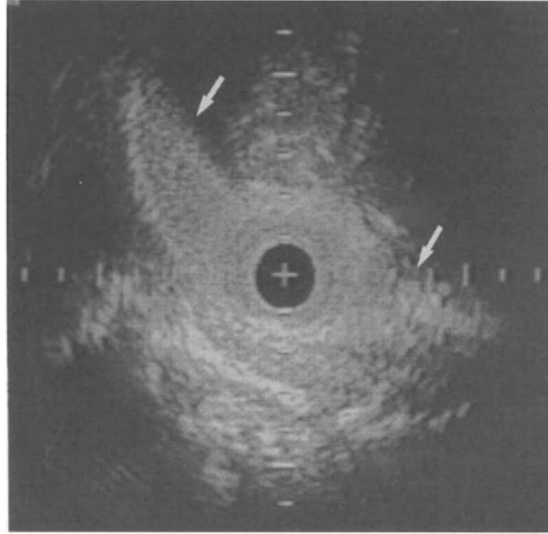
In vivo intravascular ultrasound image of a human femoral artery after balloon dilatation. The echogenic blood clearly delineates the vascular lumen. An almost complete drop-out, however, occurs in the segments in which the vessel wall and the underlying perivascular structures (arrows) are oriented at a narrow angle with the direction of the ultrasound beam. This sudden disappearance of the vessel wall can be clearly distinguished from drop-outs due to attenuation from blood, which would lead to a more progressive reduction in echo-intensity and would mainly affect the wall opposite to the position of the catheter. Courtesy of Dr. Pieterman/Dr. Gussenhoven, Radiology Department, Dijkzigt Academic Hospital, Rotterdam. Calibration = 1 mm.
